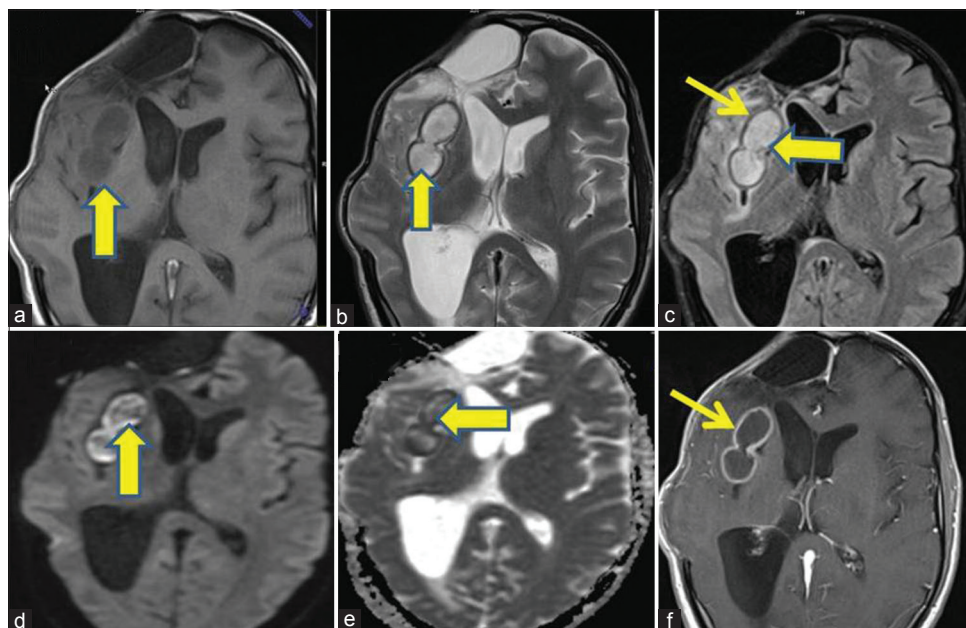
(a) Case 1: Axial T1-weighted image showing two well defined lobulated mass around right sylvian fissure abutting insular cortex (arrow) which is hypo to isointense. (b) T2-weighted axial image showing the hyperintense mass surrounded by hypointense rim. (c) Axial fluid-attenuated inversion-recovery image showing hyperintense mass with surrounding hypointense rim (thin arrow). (d and e) diffusion-weighted image at B1000 and ADC. Core of the lesion is not showing restriction of diffusion however surrounding rim shows restriction. (f) Postcontrast image showing peripheral enhancement (thin arrow). The core of lesion is not enhancing
